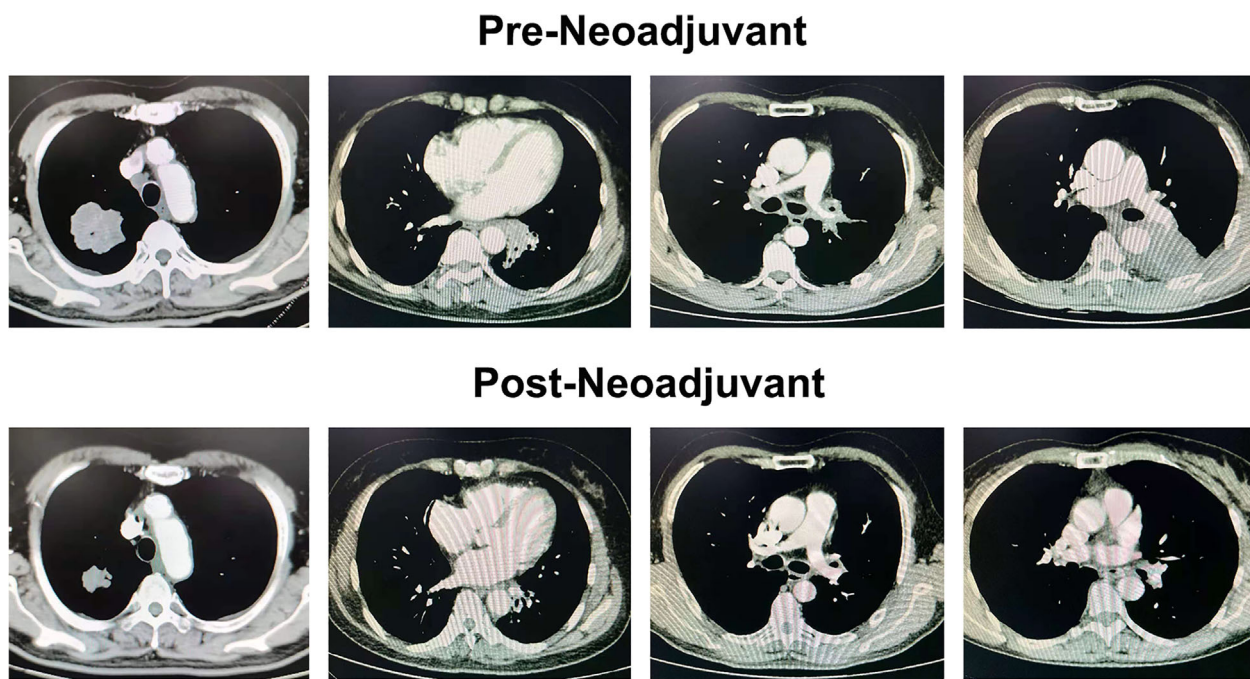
Four typical contrast enhanced computed tomography (CT) scans in patients before and after neoadjuvant chemoimmunotherapy. Neoadjuvant chemoimmunotherapy was found to reduce tumor volume, cause pathological downstaging, and raise the surgical resection rate of patients with locally advanced NSCLC
